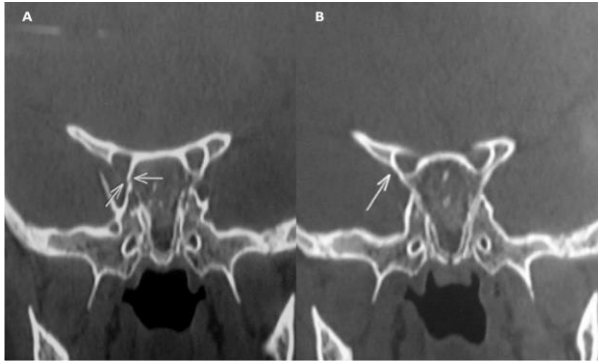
CT Orbit and Brain without contrast showing A) Fracture orbital apex B) the Fracture extending to the lateral aspect of orbital apex with indentation of optic nerve
